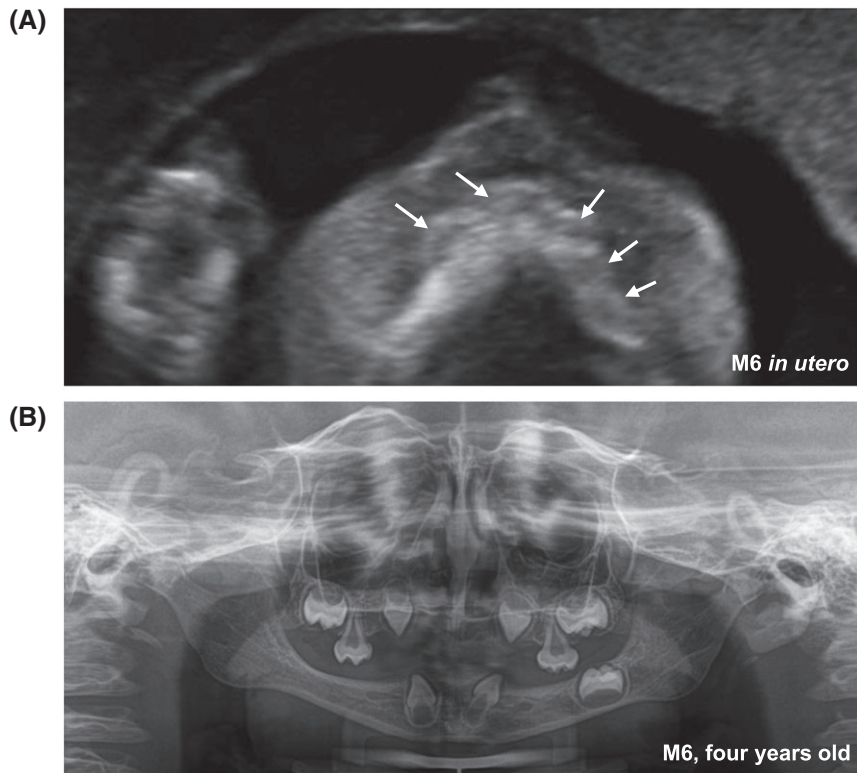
Comparison of prenatal tooth germ sonography and corresponding panoramic radiograph. A, A horizontal section of the maxilla of a fetus at 20 weeks of gestation (patient M6) shows only five tooth germs, highlighted by white arrows. On the basis of this finding, X-linked hypohidrotic ectodermal dysplasia (XLHED) was diagnosed. B, Panoramic dental radiograph of the same patient at the age of 4 years
